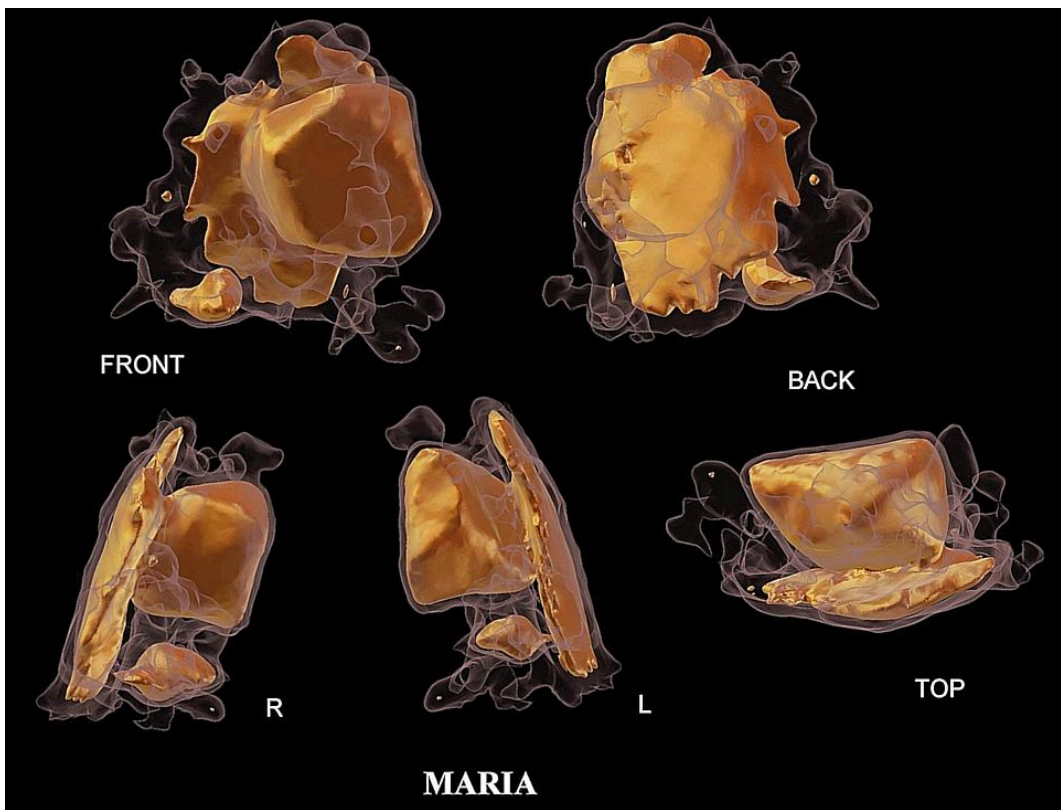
3D CT showing the sacral cavity in semi-transparency and the metallic foreign bodies (*in gold*).
